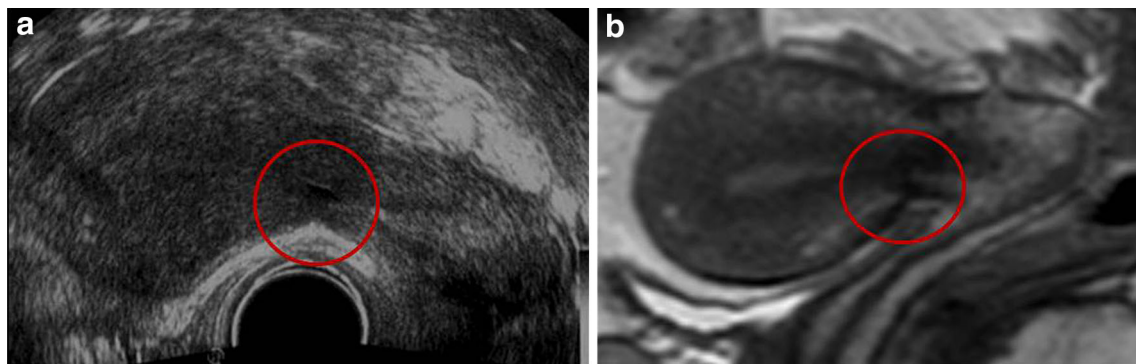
40-year-old woman with one caesarean delivery. a TVUS image of caesarean scar classified as linear. b Para-sagittal T2 Ssh-TSE MR image of the same scar classified as linear
